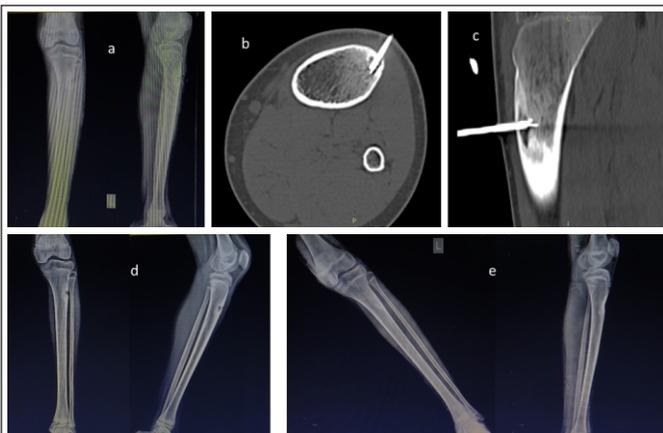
(a) Osteoid osteoma lesion in the proximal tibia in anteroposterior and lateral view radiograph, (b-d) its treatment with radiofrequency ablation and (e) healing of lesion at 12 weeks follow-up radiograph.
